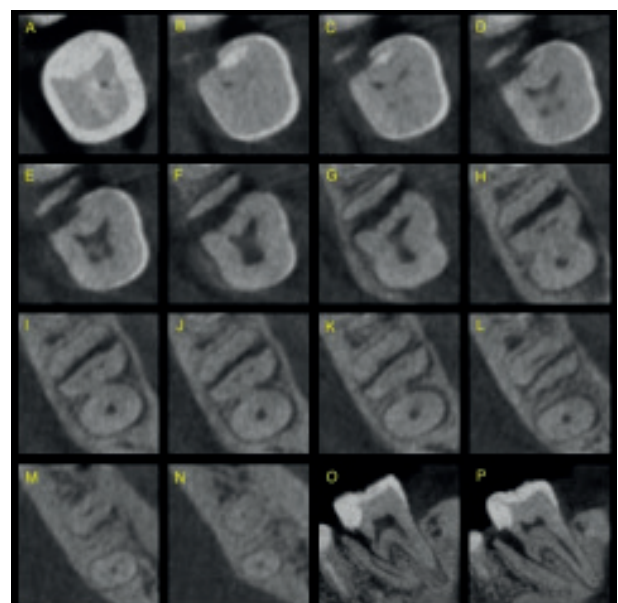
A 12-month follow up cone beam computed tomography scans of tooth: (A–N) consecutive axial cone beam computed tomography images; (O–P) selected sagittal cone beam computed tomography images. Apical fractured fragment visibly shorter than on previous cone beam computed tomography sagittal scans
